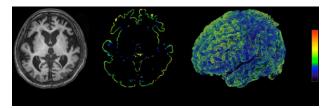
Color-coded map of cerebral cortical thickness for an AD case produced by the proposed method: (a) an original MR image, (b) an axial image, (c) a 3D image.
